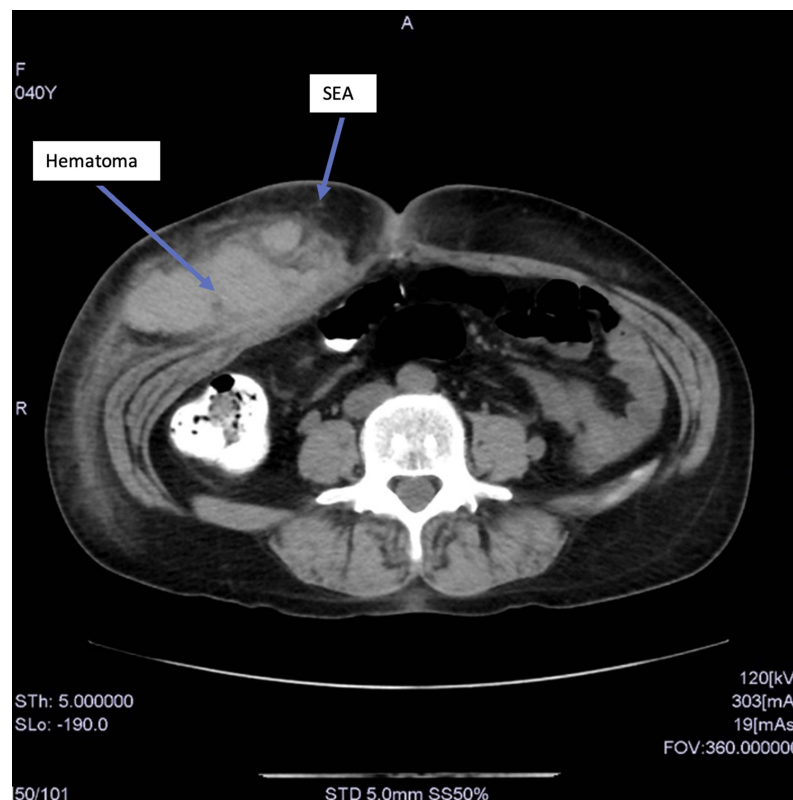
CT scan of the subcutaneous hematoma 4 hours after onset. The hematoma is superficial to the right rectus abdominis muscle (RAM). Both RAMs show marked thinning. A small vessel is visualized anteromedial to the hematoma, and suspected to be the right superficial epigastric artery (SEA).
